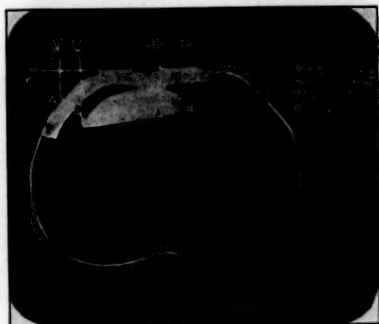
ML X=9.8—actual measurement from x-ray plate.
